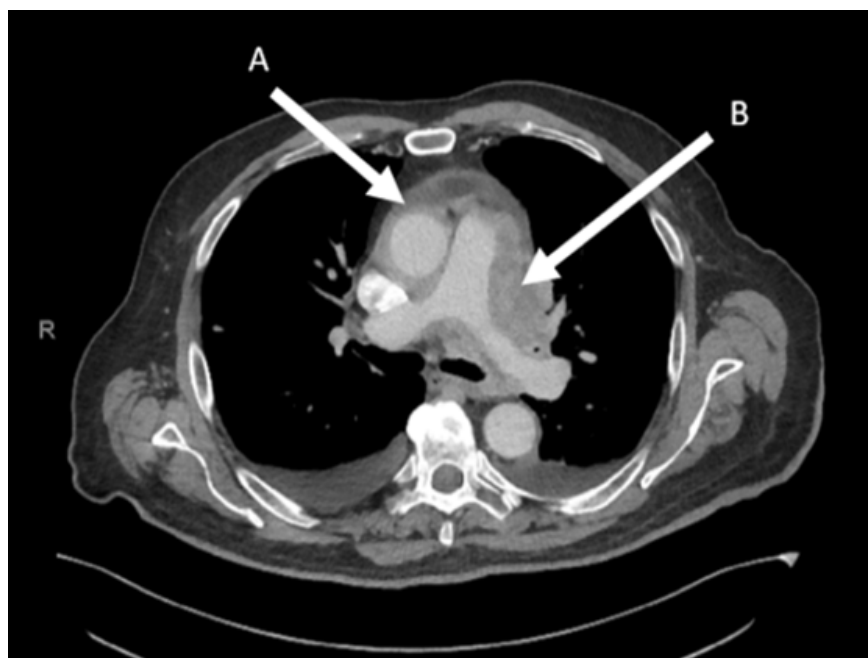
Axial CT scan showing global pericardial effusion (A) and an irregular soft tissue mass (B).
